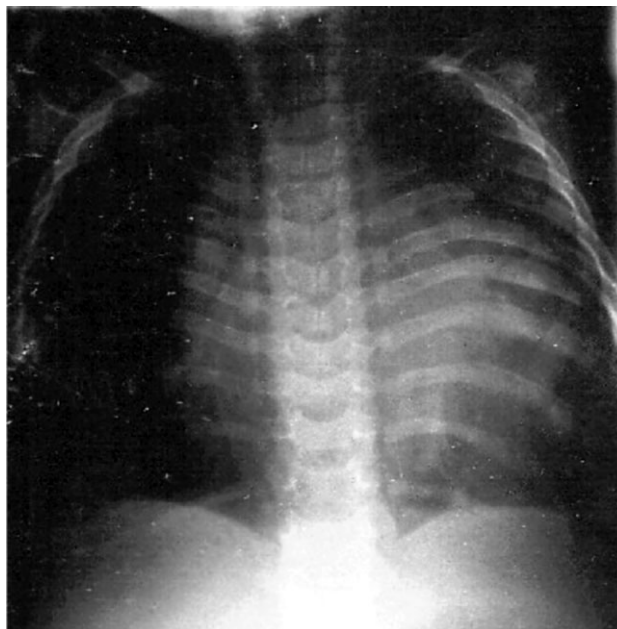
X-ray at 11 months of age.
